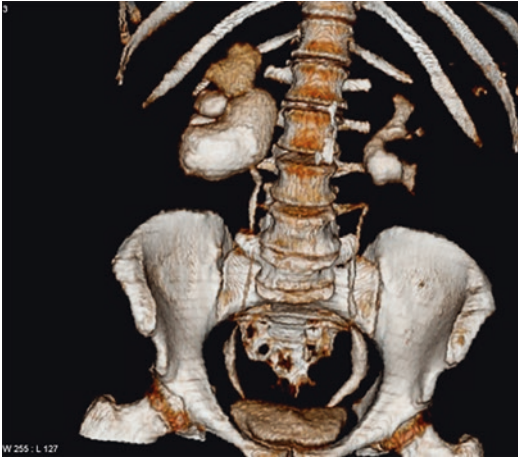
3-D CT in renal anomaly. (3-D CT reconstruction in a patient with bilateral UPJ stenosis, showing the large stone burdens and the upper urinary tract in rich 3-D format that may be rotated to visualize the system from all directions, in order to plan optimal access)
